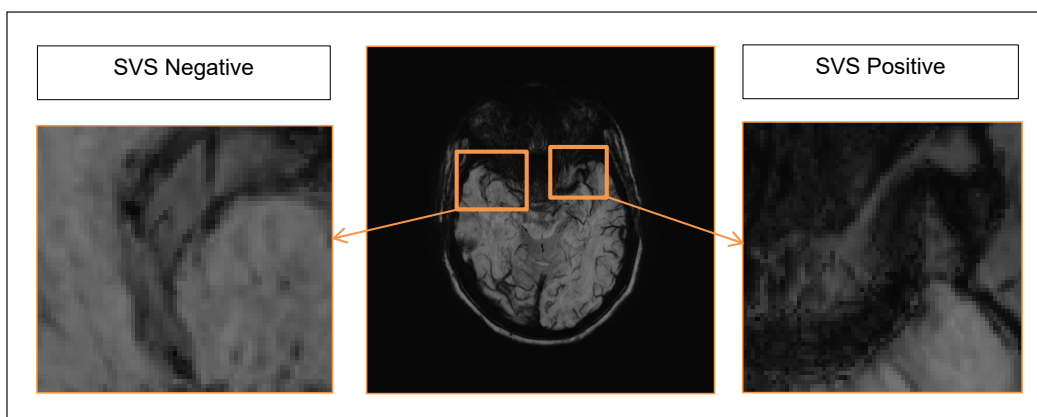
This is one of the image slices taken from acute ischemic stroke patients using the MRI modality with the SVS positive. This image is cropped into the negative SVS region and the positive SVS region that is used during the experiment
